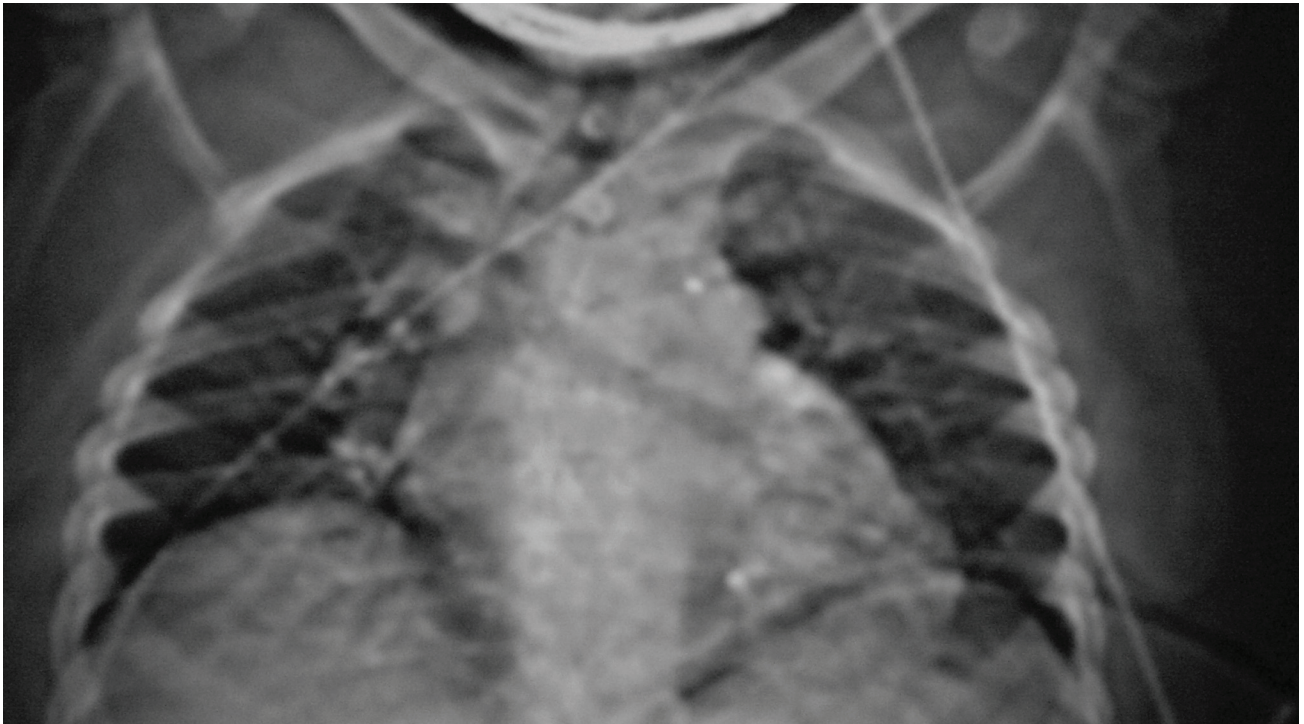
Chest radiograph. Note multiple metal fragments in left chest.*
